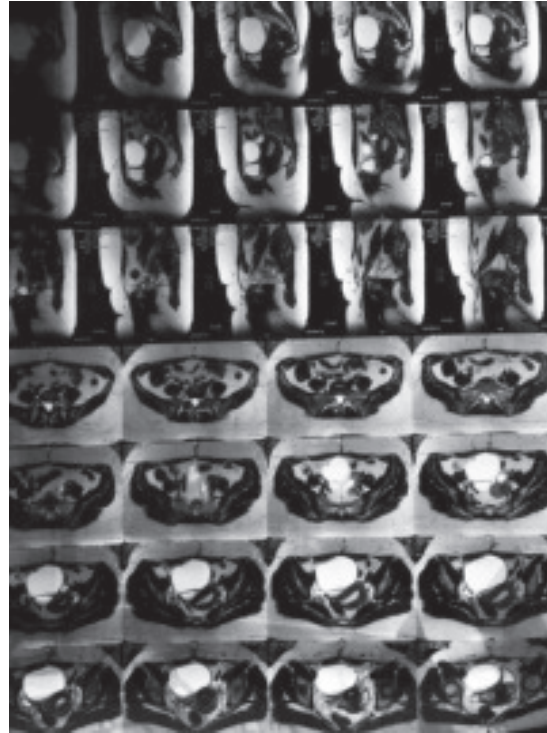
Case 3, MRI shows a focal well defined cystic lesion arising from right ovary appearing hyperintense on both T₁ & T₂ weighted sequence which is not suppressed on fat saturated images suggestive of haemorrhagic content. The lesion shows fluid fluid levels with T₂ shading effect suggesting endometrioma. Left ovary and uterus- Normal.
